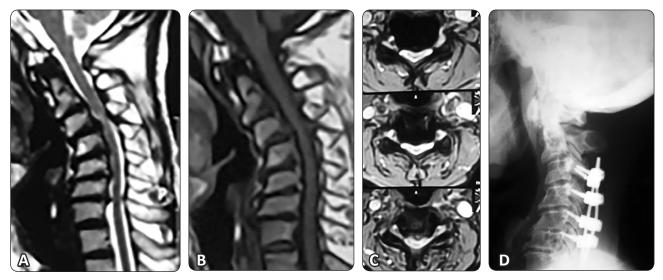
48-year-old man suffered from multi level cervical discs C3/4, C4/5, C5/6, C6/7, he also instability at C3/4 level and progressive kyphosis. (A,B,C) Preoperative MRI demonstrated that the cervical canal was extremely narrowed with flattening of the cord but no cord malacia. The patient underwent multilevel posterior laminectomies and lateral mass fusion C3-C6. (D) Postoperative lateral X-ray showing satisfactory laminectomies and screws. The patient improved clinical on JOA from 11 to 14 and Nurick DI from 3 to 4.
